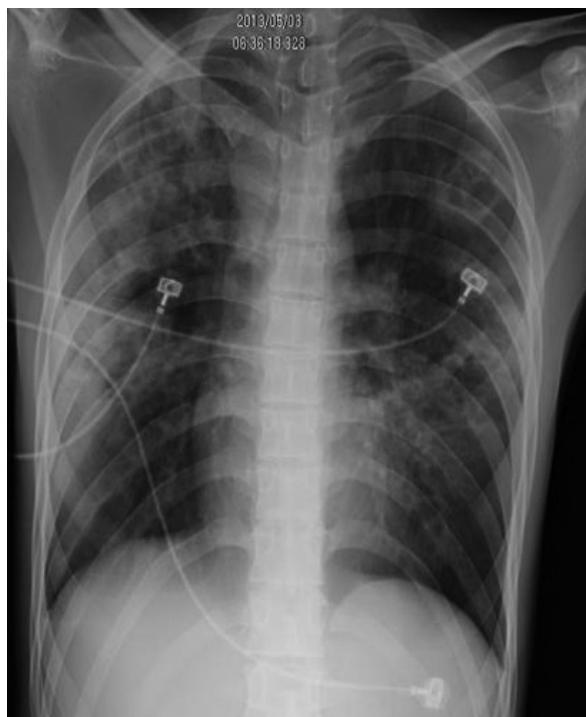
Chest radiography on May 3, 2013 shows improving alveolar infiltrates; however, multiple cavitory lesions were observed in the patches.
